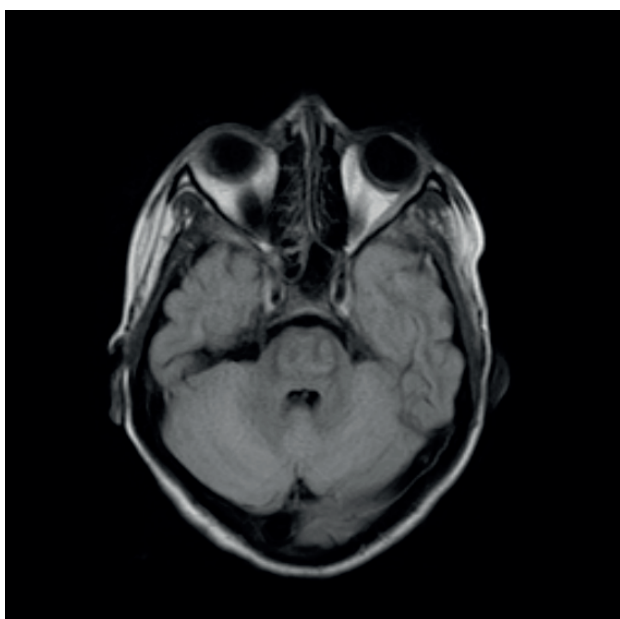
FLAIR hyper intensity in pons.
